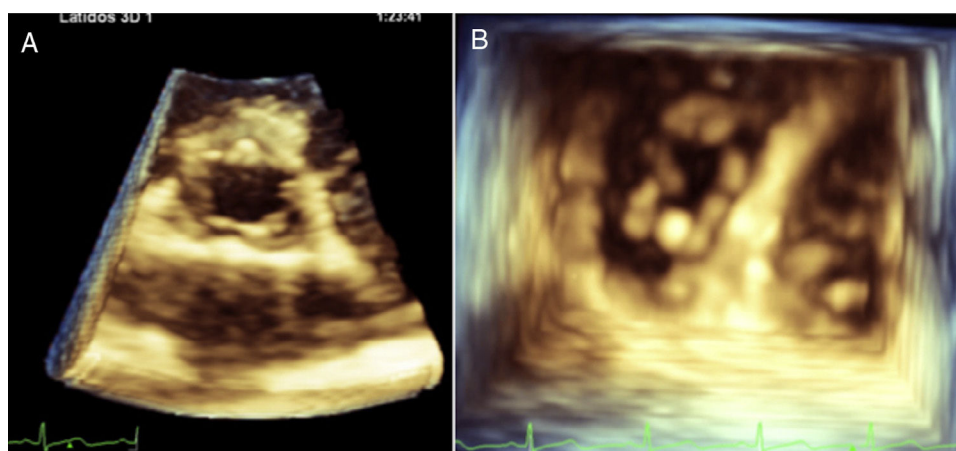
Transthoracic three-dimensional echocardiogram of the aortic valve with small nodules in the edges (A). Transthoracic three-dimensional ventricular view of the tricuspid valve in diastole, showing prominent nodules in their cusps (B).
